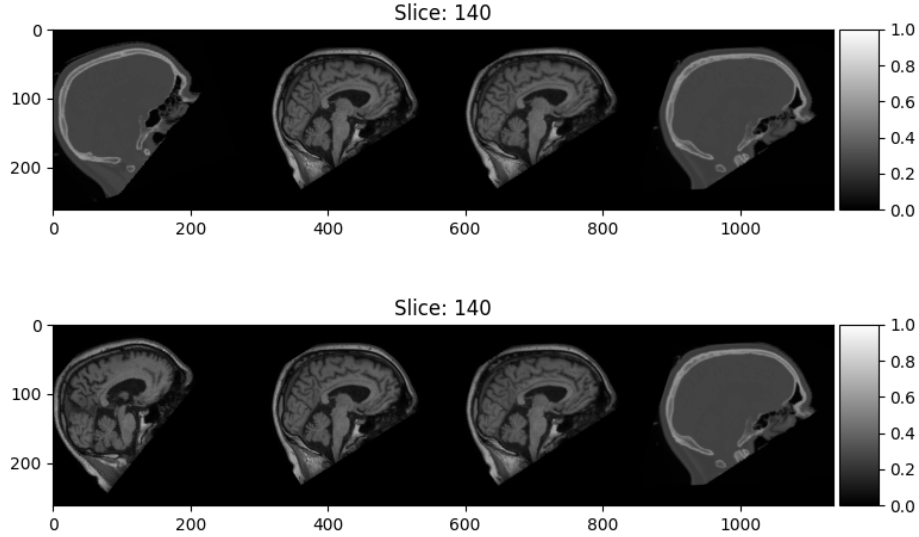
Examples showing a 2D slice of a registered image. From left to right: moving, fixed, moved MRI, moved CT. The moving images have been subject to the exact same transform, for ease of comparison. The moved images in the top row have been moved according to the affine transform found by registering the moving CT to the fixed MRI. The bottom row is transformed according to the moving MRI.
